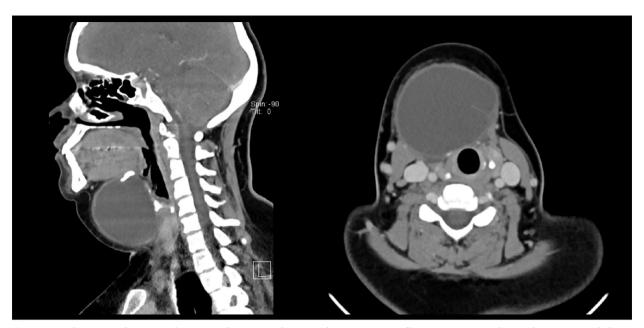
Neck computed tomography scan with contrast showing a homogenous, midline cystic mass with an enhancing rim. Slight deviation to the left is noted on axial section (right).
